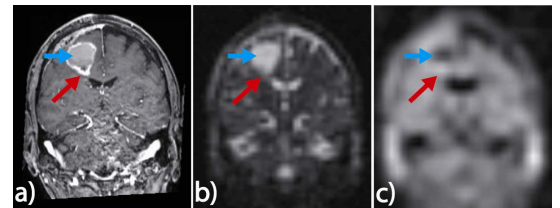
Images of a glioblastoma patient after tumor-resection. a) contrast-enhanced T_1 -image. b) ^{23}Na -conc. c) ^{23}Na -FLAIR (TE/TR = 0.75/190 ms; TI = 37 ms; resolution: (5.5 mm)³; Hamming-filtering; $T_{AQ} = 10$ min 20 s). The resection-cavity is suppressed in the ^{23}Na -FLAIR-image (blue arrow), whereas the enhancing part (red arrow) shows a high signal.
